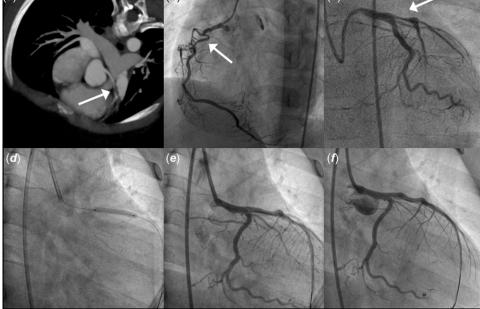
The CT and coronary angiography before and after percutaneous coronary intervention (PCI). (*a*) CT before PCI depicted moderate stenosis at the proximal of the left anterior descending coronary artery (LAD, White arrow). (*b*) Right coronary angiography before PCI showed complete occlusion of the right coronary artery with bridge collaterals formation (White arrow). (*c*) Coronary angiography before PCI developed localised tight stenosis just at the proximal portion of the LAD (White arrow). (*d*) Drug-coated balloon (DCB) angioplasty with a 3.0 mm × 20 mm SeQuent Please was performed. (*e*) Left coronary angiography immediately after DCB angioplasty showed a well-dilated LAD. (*f*) Coronary angiography at 6-month follow-up showed no thrombus or restenosis in the LAD.
